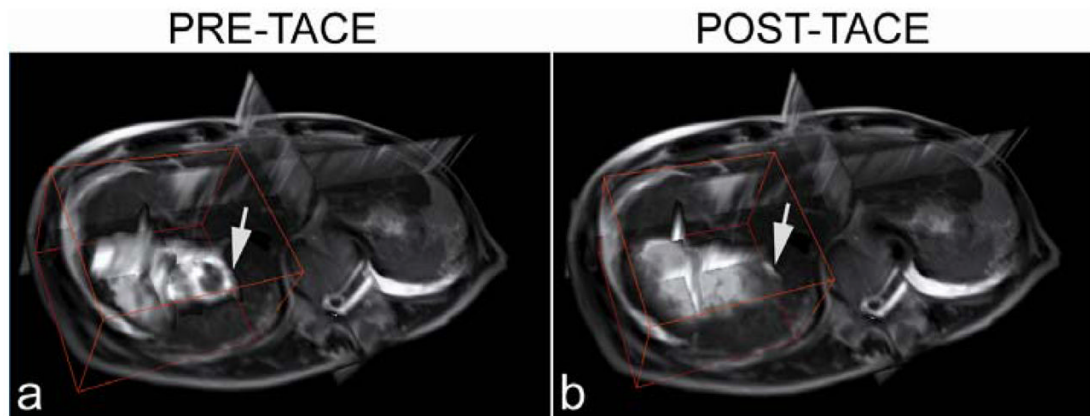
Quantitative 4D intra-procedural F_p maps co-registered to T2-weighted anatomic images acquired during x-ray DSA-MRI monitored TACE in an 81-year-old patient with segment VII HCC. These F_p maps provide localized intra-procedural perfusion information with volumetric coverage within the targeted treatment region. Arrows indicate tumor position.
